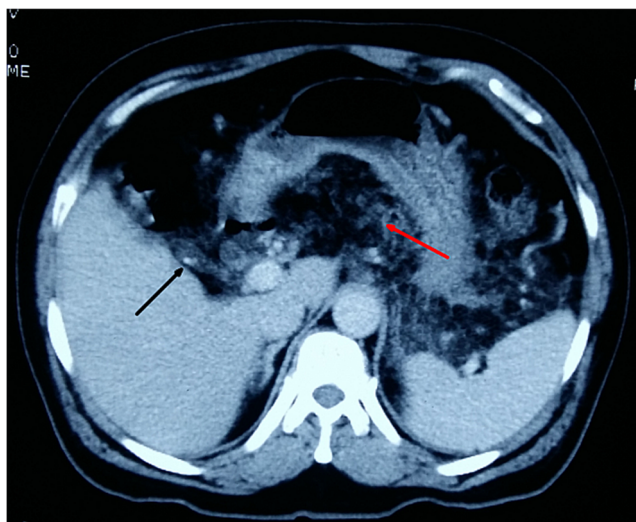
Contrast CT of the abdomen showing peripancreatic stranding (red arrow) due to acute pancreatitis with a sac-like structure with radiopaque densities within it (black arrow)
